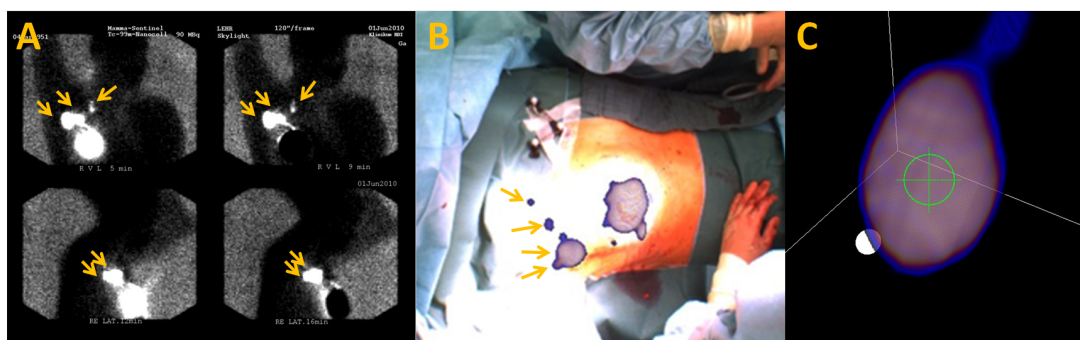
(A) Planar scintigraphy of patient showing several SLNs up to subclavicular area. (B) Augmented reality visualization of freehand SPECT image of same patient. (C) 'Probe view' of the major hot spot used for 3D navigation.
